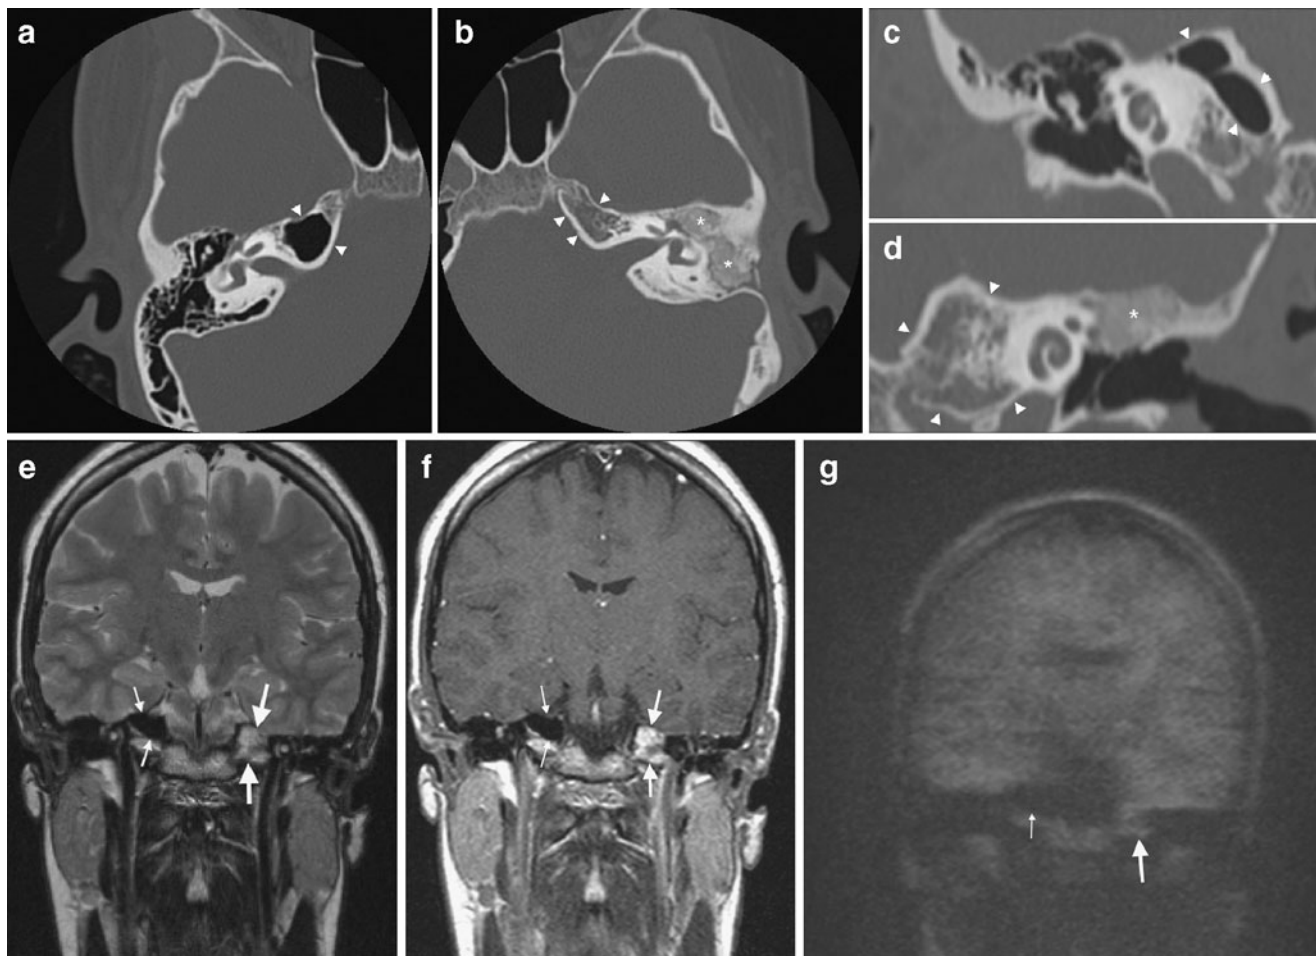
A 16-year-old female with a history surgery for left-sided middle ear cholesteatoma. A primary bony obliteration technique was performed. a Right-sided axial CT scan at the level of the tympanic segment of the facial nerve. There is a clear aeration of the apex of the right petrous bone (*arrowheads*). b Left-sided axial CT scan at the level of the tympanic segment of the facial nerve (same level as a). There is a non-aerated apex of the left petrous bone (*arrowheads*). Note the PBOB technique in the left mastoid in which the entire mastoid is filled with a mixture of bone and bone paté, obliterating the entire mastoid and epitympanum (*asterisks*). c Coronal CT reformation at the level of the cochlea. There is a clear aeration of the apex of the right petrous bone (*arrowheads*). d Coronal CT reformation on the left side (same level as c). Note the lack of aeration (*arrowheads*) and the obliterated aspect of the epitympanum (*asterisk*). e Coronal 2-mm TSE T2-weighted image (same level as c and d). Asymmetry at the level of the apex of petrous bone. The hypointensity on the right side is explained by the presence of air in the aerated apex (*small arrows*). The hyperintensity on the left side is explained by the presence of fat containing bone marrow in the apex of the left petrous bone apex (*large arrows*). f Coronal post-gadolinium SE T1-weighted image
